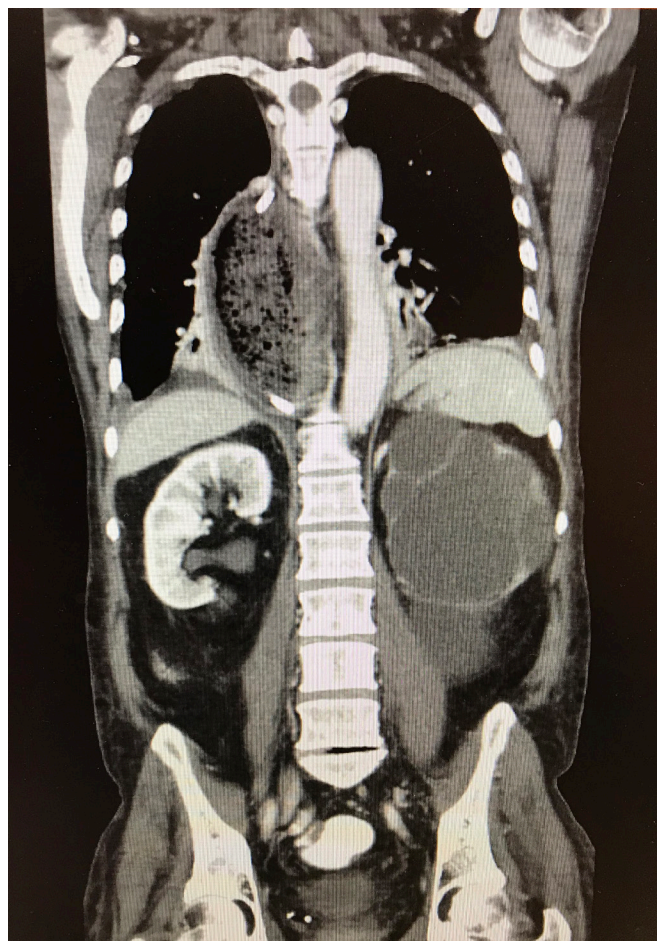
CT abdomen and pelvis showing a dilated oesophagus secondary to compression of the stomach by the large left hydronephrosis.
